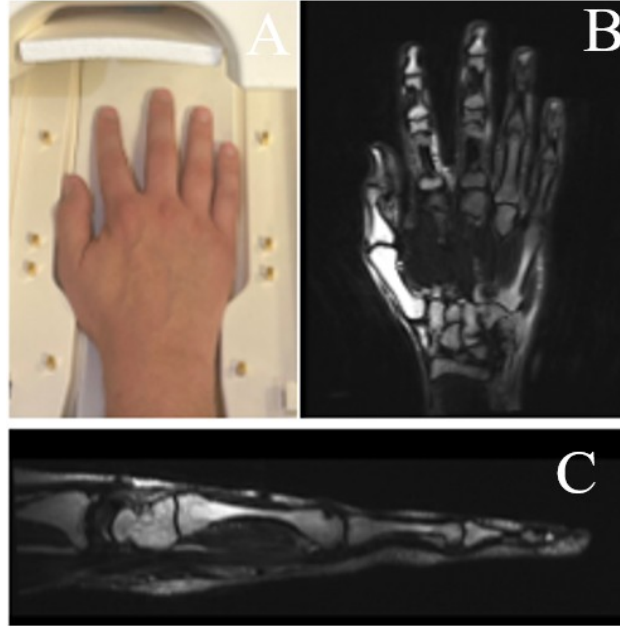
Figure 2.3A shows the participant's hand in a hand coil used to provide support and enhance clear imaging of the hand under MRI. Bone, tendon, ligaments, and muscle are all visible under MRI, as well as the hand structure. Figure 2.3B shows a MRI of the hand in the pronate position. Figure 2.3C shows the lateral plane view of the MRI image. The images are used to create digital 3D models of anatomy.
